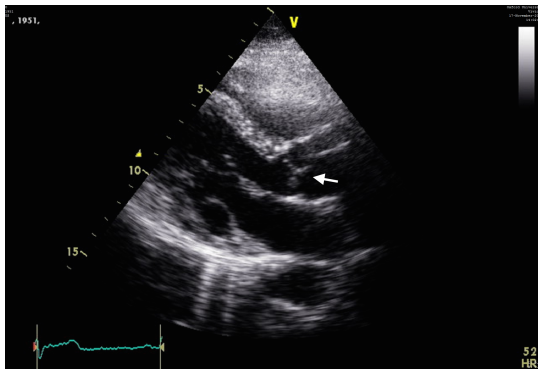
An image of measurement of the diameter of the aortic root. The two-dimensional Doppler image shows a parasternal long-axis view of heart. The location of the aortic root is indicated by an arrow.
